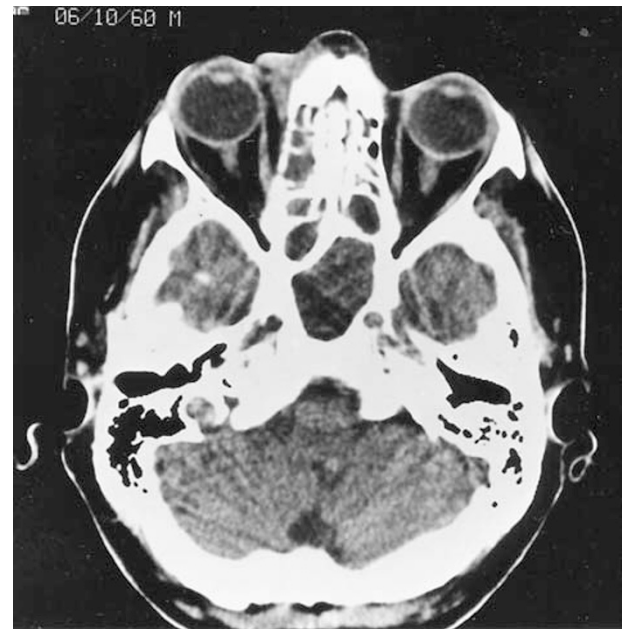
CT scan of the brain and orbits showing extensive sinusitis and soft tissue swelling anterior to the right globe.
